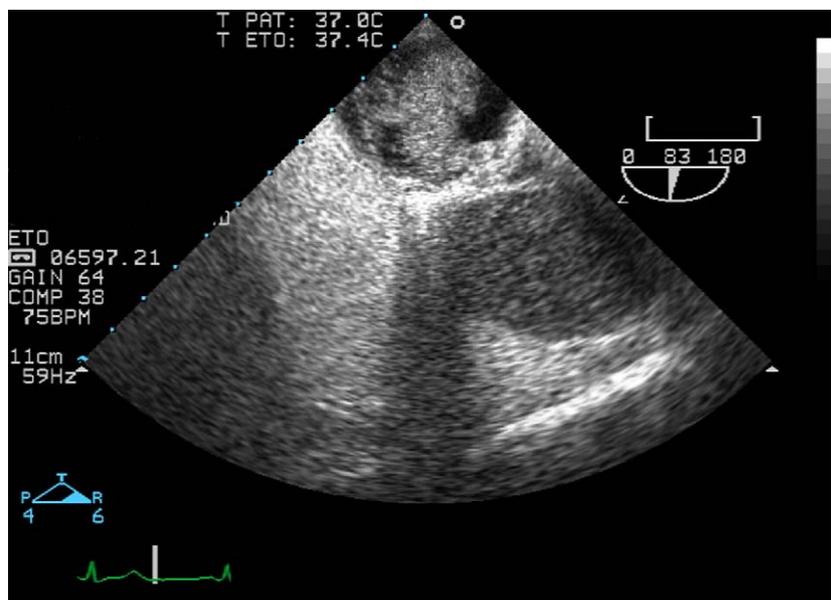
Large shunt with transesophageal echocardiography.
